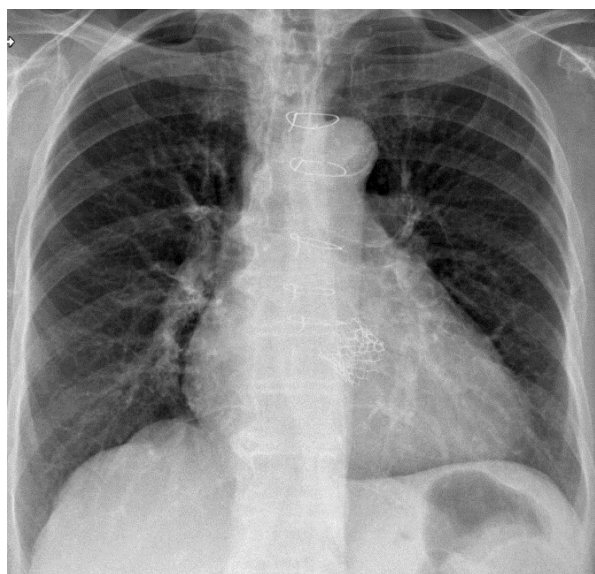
Chest X-ray after TAVI-in-TAVI reflecting the complex medical journey of the patient: sternum wires from the first CABG surgery and the two prosthetic stents from the first TAVI and the second TAVI-in-TAVI superposed in the center of the X-ray.
